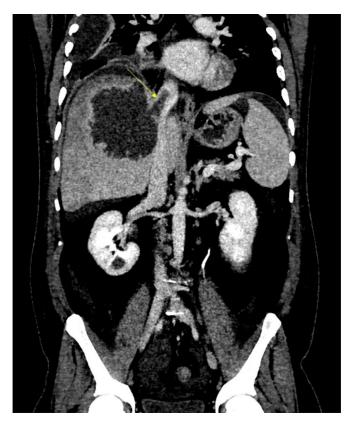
Case 2: Contrast-enhanced CT coronal showing a hypodense filling defect in the IVC, which is communicating with the liver abscess (yellow arrow).
